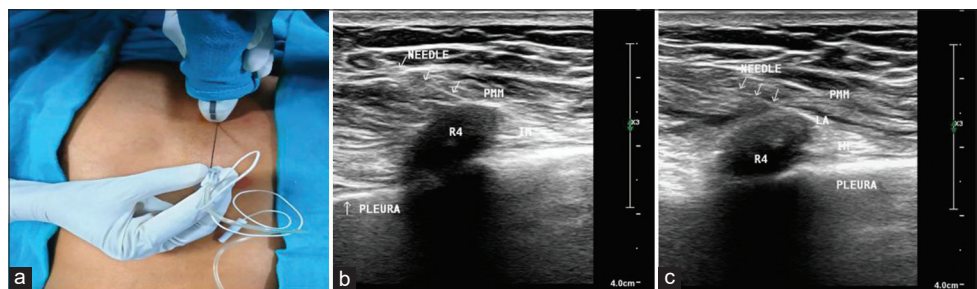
Depiction of the ultrasound (USG) probe placed 2–3 cm lateral to the corresponding sternal border (a); Sonoanatomy of pecto-intercostal fascial plane (PIFB) with in-plane needle tract and the tip visualized between the pectoralis major (PMM) and the intercostal muscle (b); USG-image showing the LA agent injected into the PIFB (c). One can note the glistening white structure as the pleura where R4 denotes the fourth rib.
